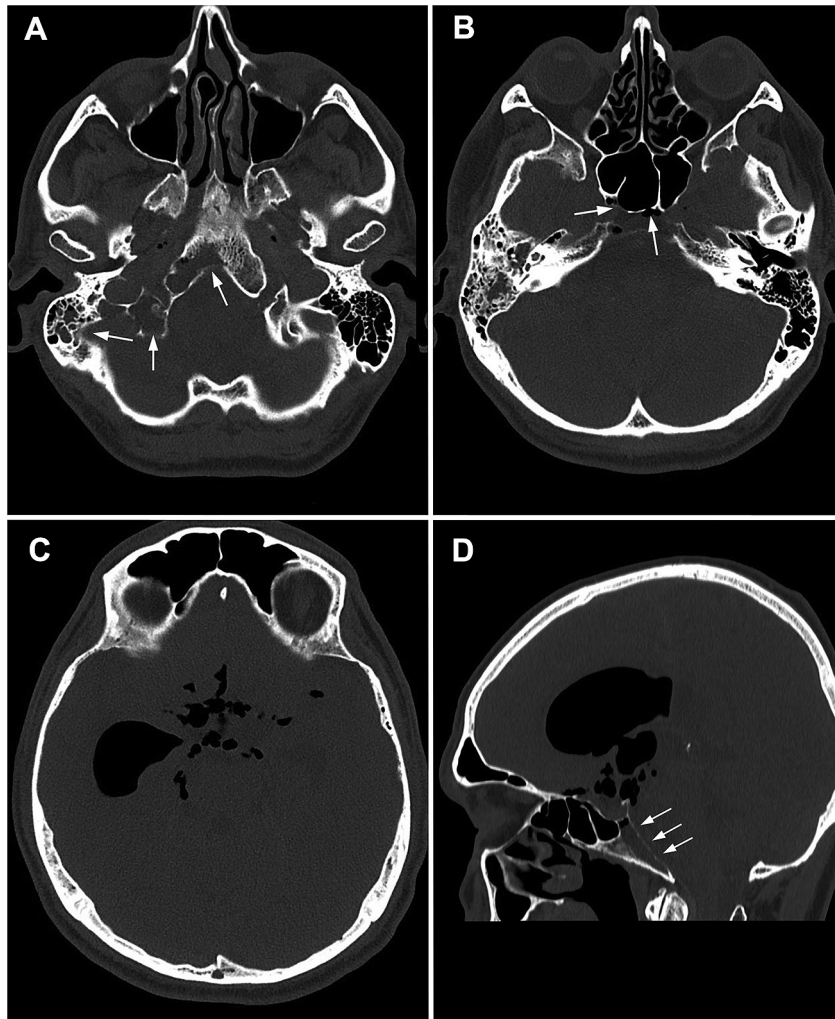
Cerebral computed tomography scan, bone windows. (A) Axial slice showing the lysis of the basal-occipital bone and the mastoid (arrows). (B) Axial slice showing the lysis of the wall of the sphenoid sinus (arrows). (C) Axial slice showing hydrocephalus and ventricular and cisternal pneumocephalus. (D) Sagittal slice showing the osseous lysis of the clivus (arrows).
